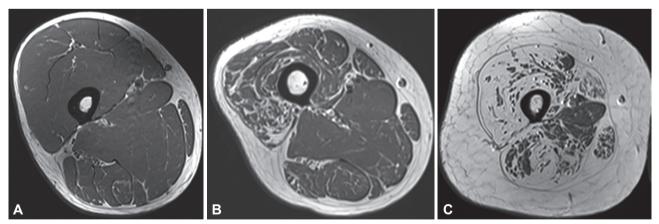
Thigh MRI images of CMT2K patients with varying degrees of intramuscular fatty infiltration according to different mutation sites. A: Axial T1-weighted MRI image at the mid-thigh level of a 48-year-old male (FC1085/II-1, R120W mutation) showing nearly normal muscles with minimal fatty streaks. B: MRI image of a 53-year-old male (FC407/I-1, R226K mutation) with moderate fatty degeneration centered in the anterior-compartment muscles. C: MRI image of a 43-year-old female (FC008/II-3, Q218E mutation) showing severe fatty infiltration that is most pronounced in the anterior- and posterior-compartment muscles. CMT2K: Charcot-Marie-Tooth disease type 2K, MRI: magnetic resonance imaging.
